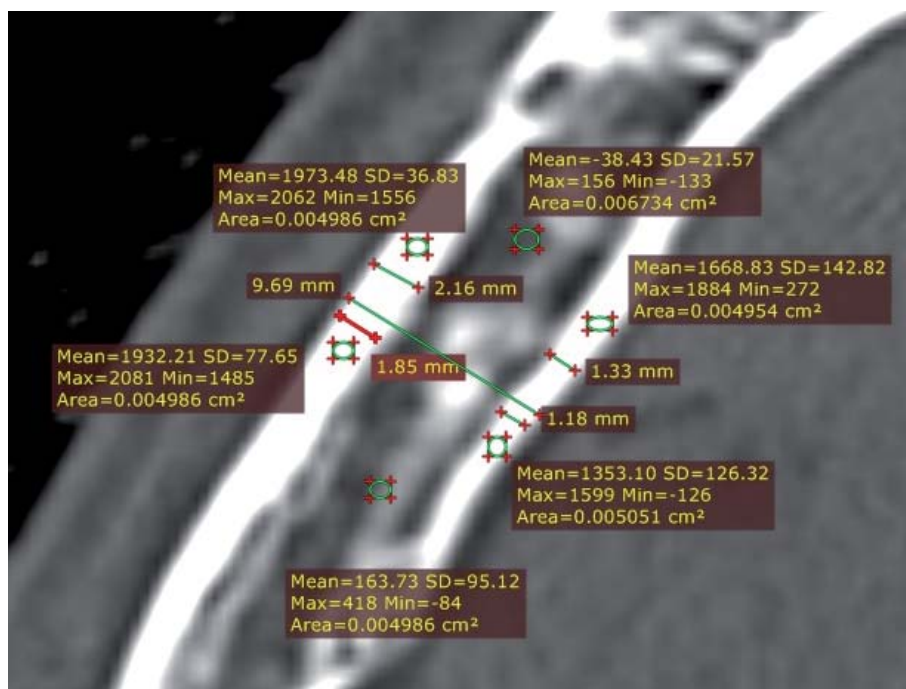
Determination of the thickness and radiological density of different bone layers according to CT data in the axial section of the LJ in the projection of the first molar
